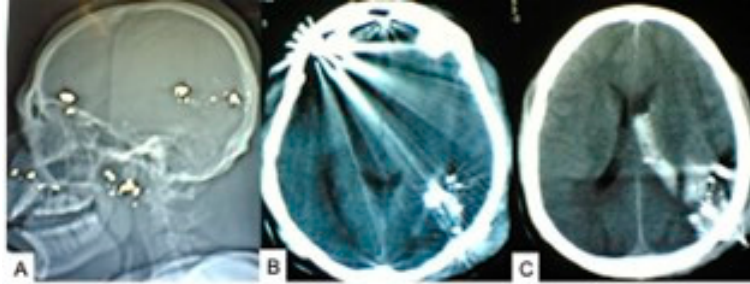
(A) X-ray of the skull (lateral view) showing multiple retained bullet fragments in different sites of the head. (B,C) CT scan (axial views) showing multiple retained bullet fragments with artifacts and parenchymal and lateral ventricular hemorrhages, respectively. Source: Figure by authors.
